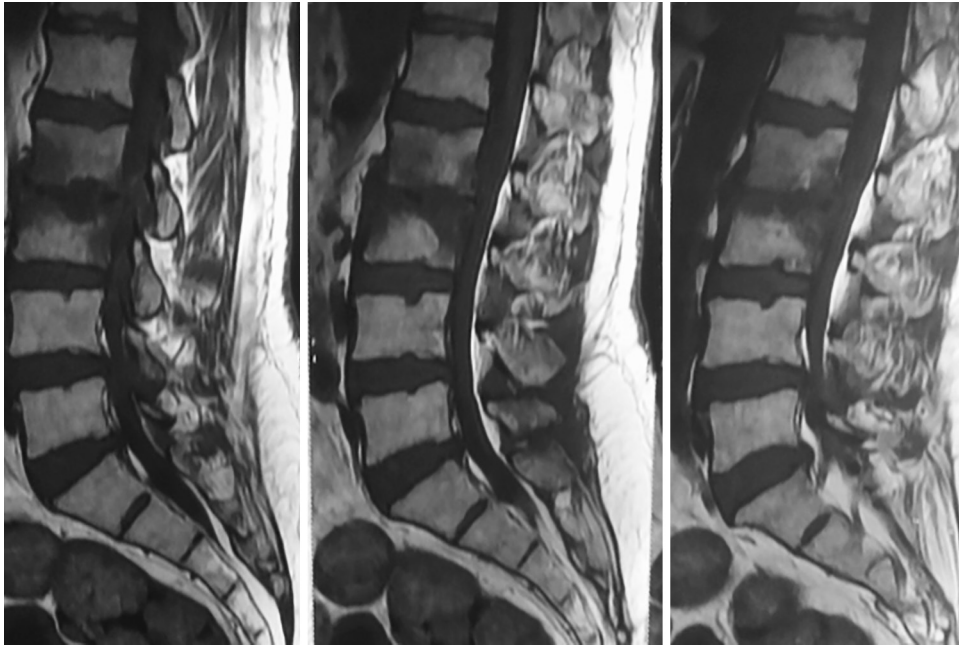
MRI T1 weighted sagittal image showing altered signal intensity at L2 and L3 end plates
